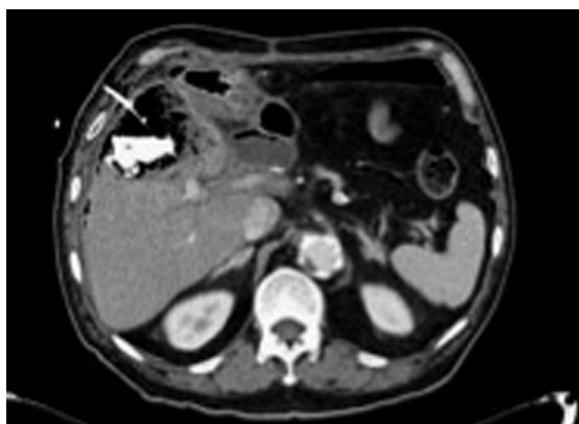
Contrast CT scan of the abdomen made two hours after the percutaneous drainage. The amount of gas accumulation is the same as in the previous examination. Enhanced material was present in the area with accumulated gas.
